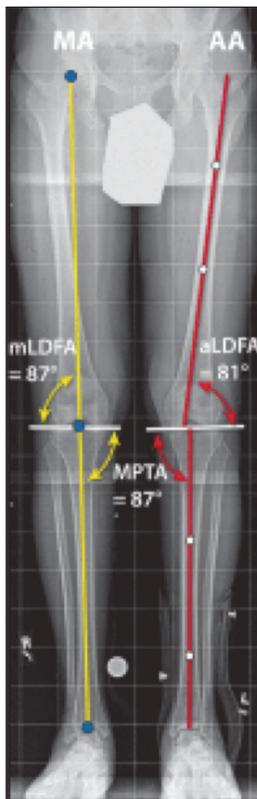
Long-leg standing radiograph demonstrating the mechanical axis of the lower extremity (MA), mechanical axis of the femur (MA)
